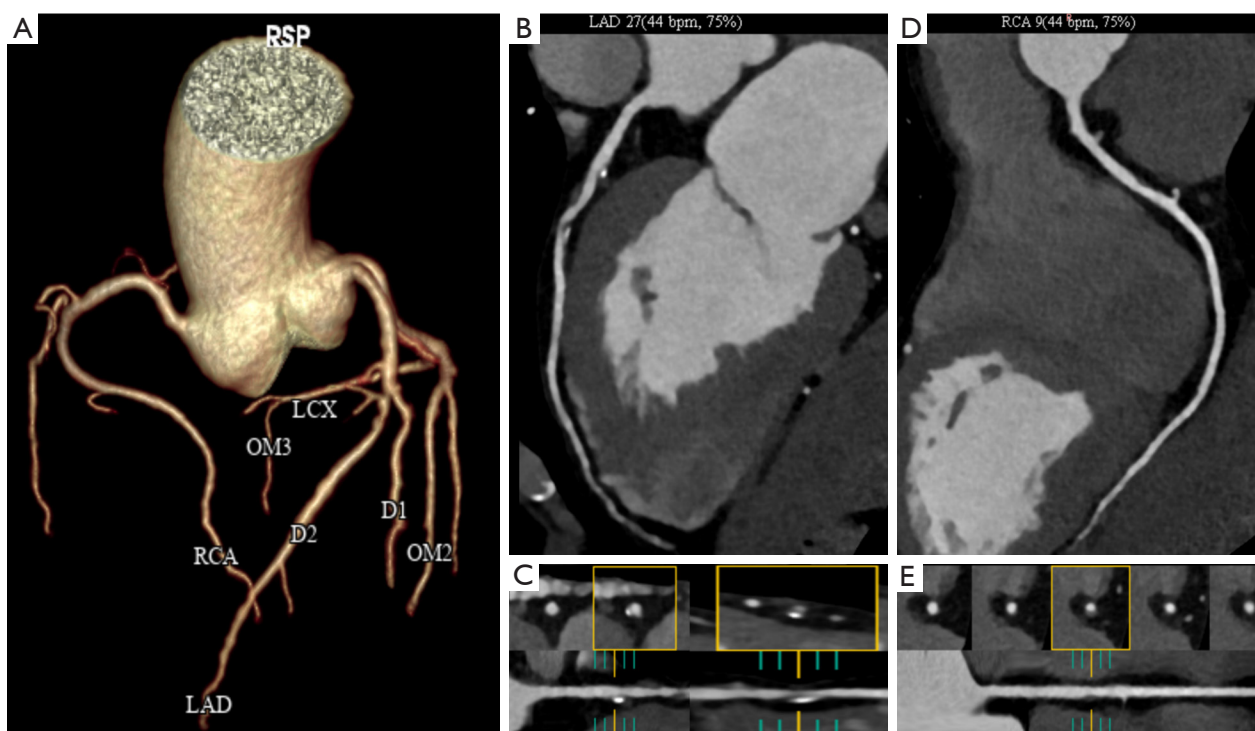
Coronary atherosclerotic plaque analysis. Images from a 69-year-old male who presented with atypical chest pain. (A) Three-dimensional volume rendering technique reconstruction from CCTA, (B) CPR of the LAD, (C) probe images of the proximal and middle segments of the LAD plaque, (D) CPR of the RCA, (E) probe images of the proximal plaque in the RCA. (B,D) Depict the corresponding coronary artery branches with different plaques outlined by dotted yellow boxes, while (C,E) show the probe images of the corresponding plaques outlined by solid yellow boxes. As shown in picture, CCTA identified a calcified plaque with mild luminal narrowing in the proximal segment of the LAD, SIS =1, SSS =1; another mixed plaque with moderate luminal narrowing was identified in the middle segment of the LAD, SIS =1, SSS =2; a non-calcified plaque with minimal luminal narrowing was identified in the proximal segment of the RCA, SIS =1, SSS =0. Therefore, the patient's total SIS was 3 (SIS =3) and the total SSS was 3 (SSS =3). CCTA, coronary computed tomography angiography; CPR, curved multiplanar reconstruction; LAD, left anterior descending; RCA, right coronary artery; SIS, segment involvement score; SSS, segment stenosis score.
